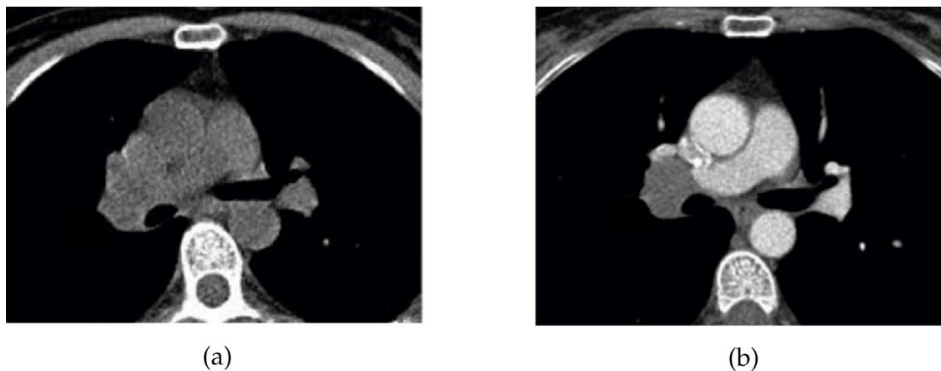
Cardiac CT images with non-contrast (a) and with contrast-enhancement (b). Adapted from Purysko et al. [41]
